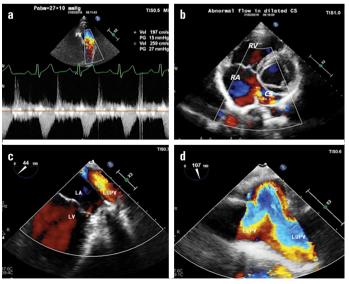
(a) Mean pulmonary arterial pressure measured on pulmonary valve was 27+10: 37 mm Hg. (b) Coronary sinus (CS) was dilated with an abnormal flow. (c) Transesophageal echocardiography showed that the left superior pulmonary vein was separated from the left atrium by a septum and was draining into CS. (d) The left upper and lower pulmonary veins were both draining into the CS.
